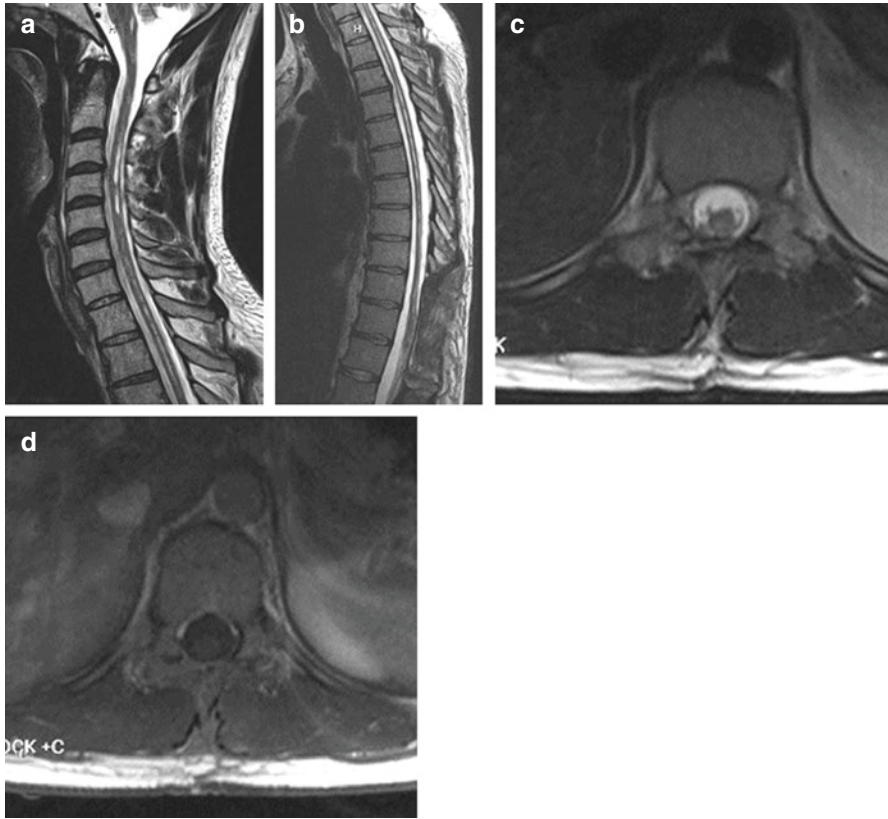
Postoperative MRI of brain of Patient 2 [58]. (a) Sagittal T2-weighted MRI of cervical spine showing syrinx collapse after tumor resection. (b) Sagittal T2-weighted MRI of thoracic spine showing syrinx collapse after tumor resection. (c) Axial T2-weighted MRI showing postoperative thoracic spinal cord after tumor resection. (d) Axial T1-weighted post-contrast MRI showing postoperative thoracic spinal cord after tumor resection
